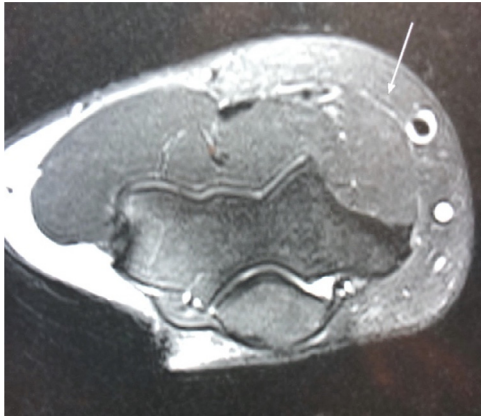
Pre-exercise axial fat saturated T2 MRI sequence of the patient's forearm, demonstrating the forearm compartments without evidence of increased signal intensity.
